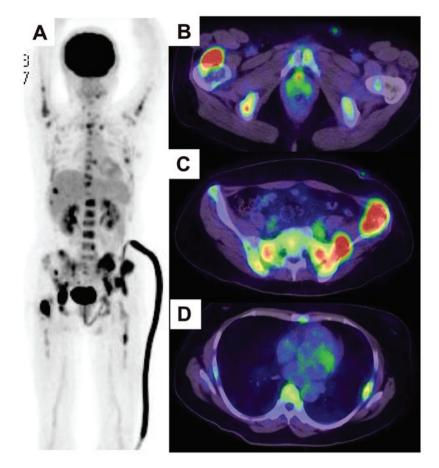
¹⁸F-fluoro-deoxy-glucose positron emission tomography (PET). (A) Whole-body PET showed multiple abnormal uptakes. (B) PET-computed tomography (CT) of the thoracic level. The SUV_{max} was 21.6 at the right axillary lymph node. (C) PET-CT of the iliac bone. The SUV_{max} was 10.2 at the left iliac bone. (D) PET-CT of the ribs showed abnormal uptakes at some ribs. The SUV_{max} was 5.46-7.82.
